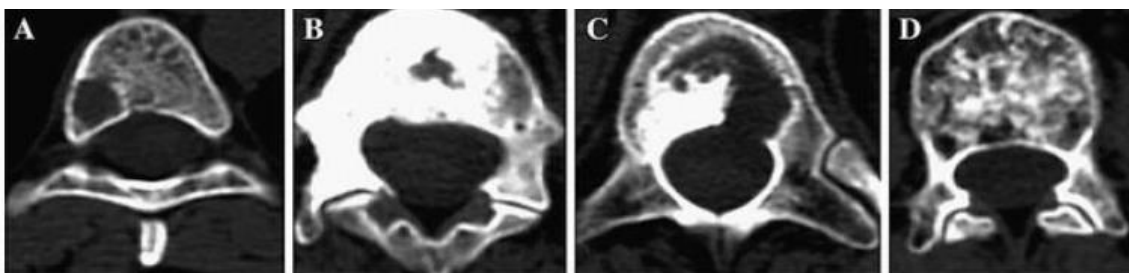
CT scan of human vertebrae with lytic metastasis (A), blastic metastasis (B), mixed localized metastasis (C) and diffuse mixed metastasis (D) [1].
